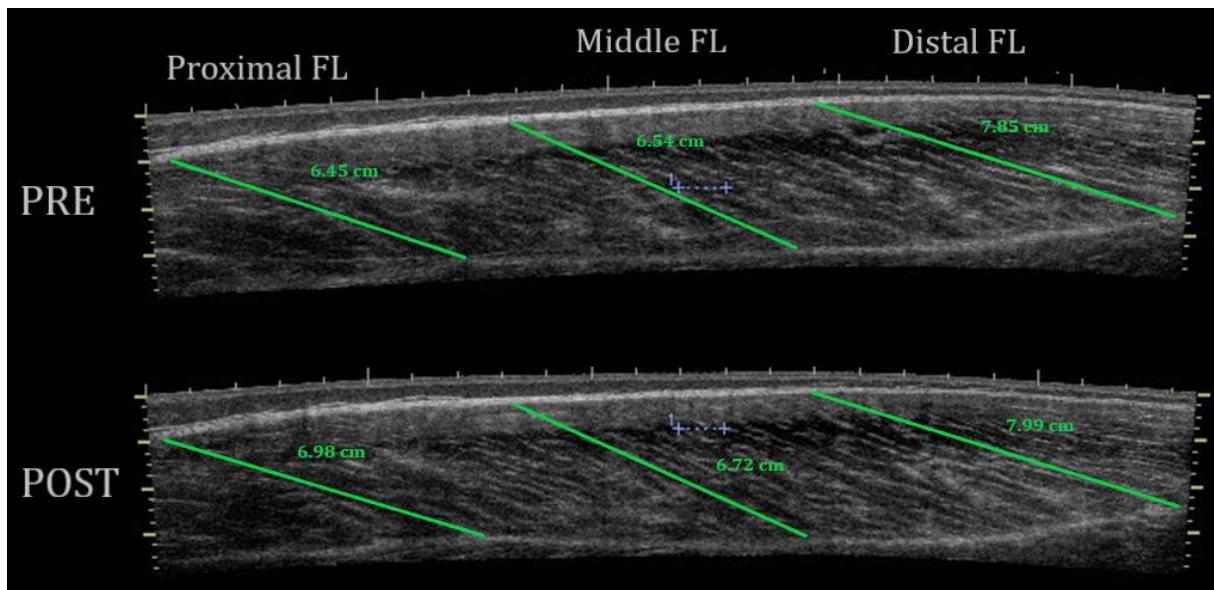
Representative extended field-of-view ultrasound evaluation of regional vastus lateralis fascicle length PRE and POST eccentric quasi-isometric condition. The dotted marker at the center of the images represents 1 cm.
